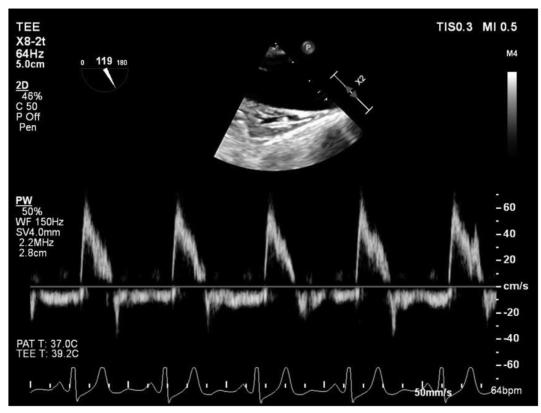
Two-dimensional TEE-guided pulsed-wave Doppler spectrum at the level of the descending aorta demonstrates low -velocity holodiastolic flow reversal, in aggregate, consistent with severe AR.
